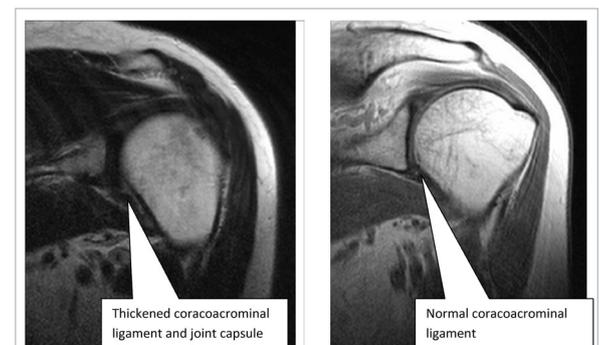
MRI pictures demonstrating difference between before and after acupuncture. Coronal (pd+t2)
